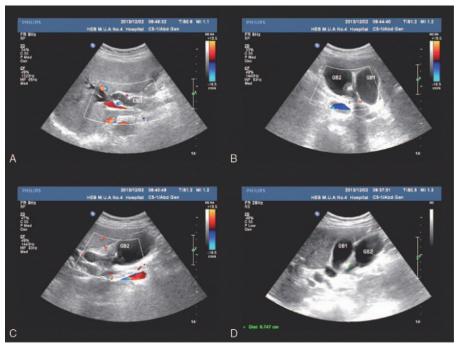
Ultrasound manifestation of the patient. (A–C) Ultrasound results showed that the morphology of the liver is normal. The common bile duct and intrahepatic bile duct are dilated. There is a low echo nodule with a lesion at the end of the common bile duct. (D) The "+" points out the location of the tumor.
